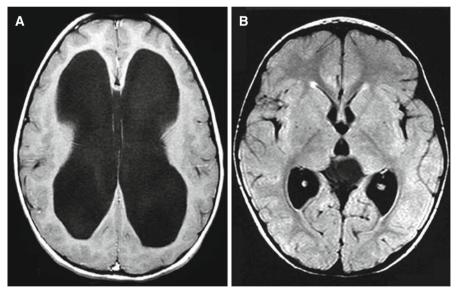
Pre-operative (A) and post-operative (B) axial MRI of a case of a supratentorial hydrocephalus treated by endoscopic third ventriculostomy
